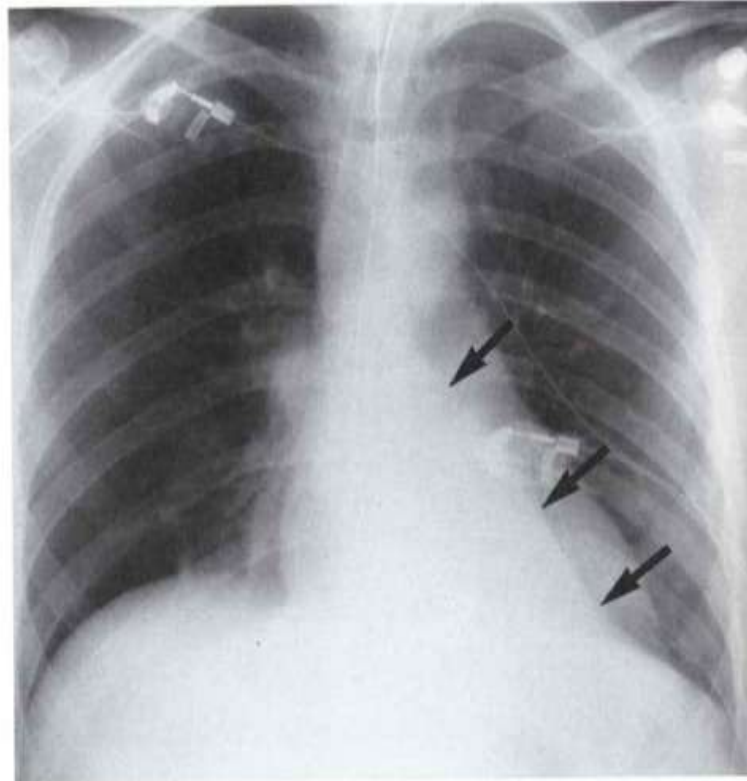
Left lower lobe collapse. AP upright chest radiograph of a 17-year-old boy shows downward and medial displacement of the left major fissure (*arrows*), a triangular area of increased opacification over the left heart, and loss of the left medial diaphragmatic contour.
